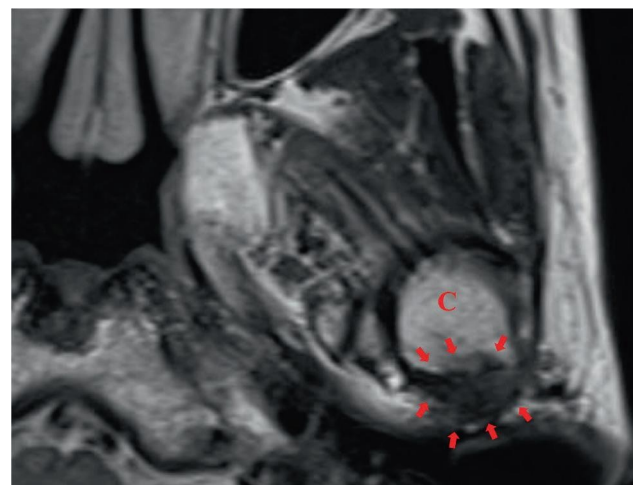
Axial T2-weighted MRI: MRI reveals a mass lesion (arrows) comprising cortical bone and bone marrow, connected to the cortical bone and bone marrow of the condyle, respectively. C, condyle.
